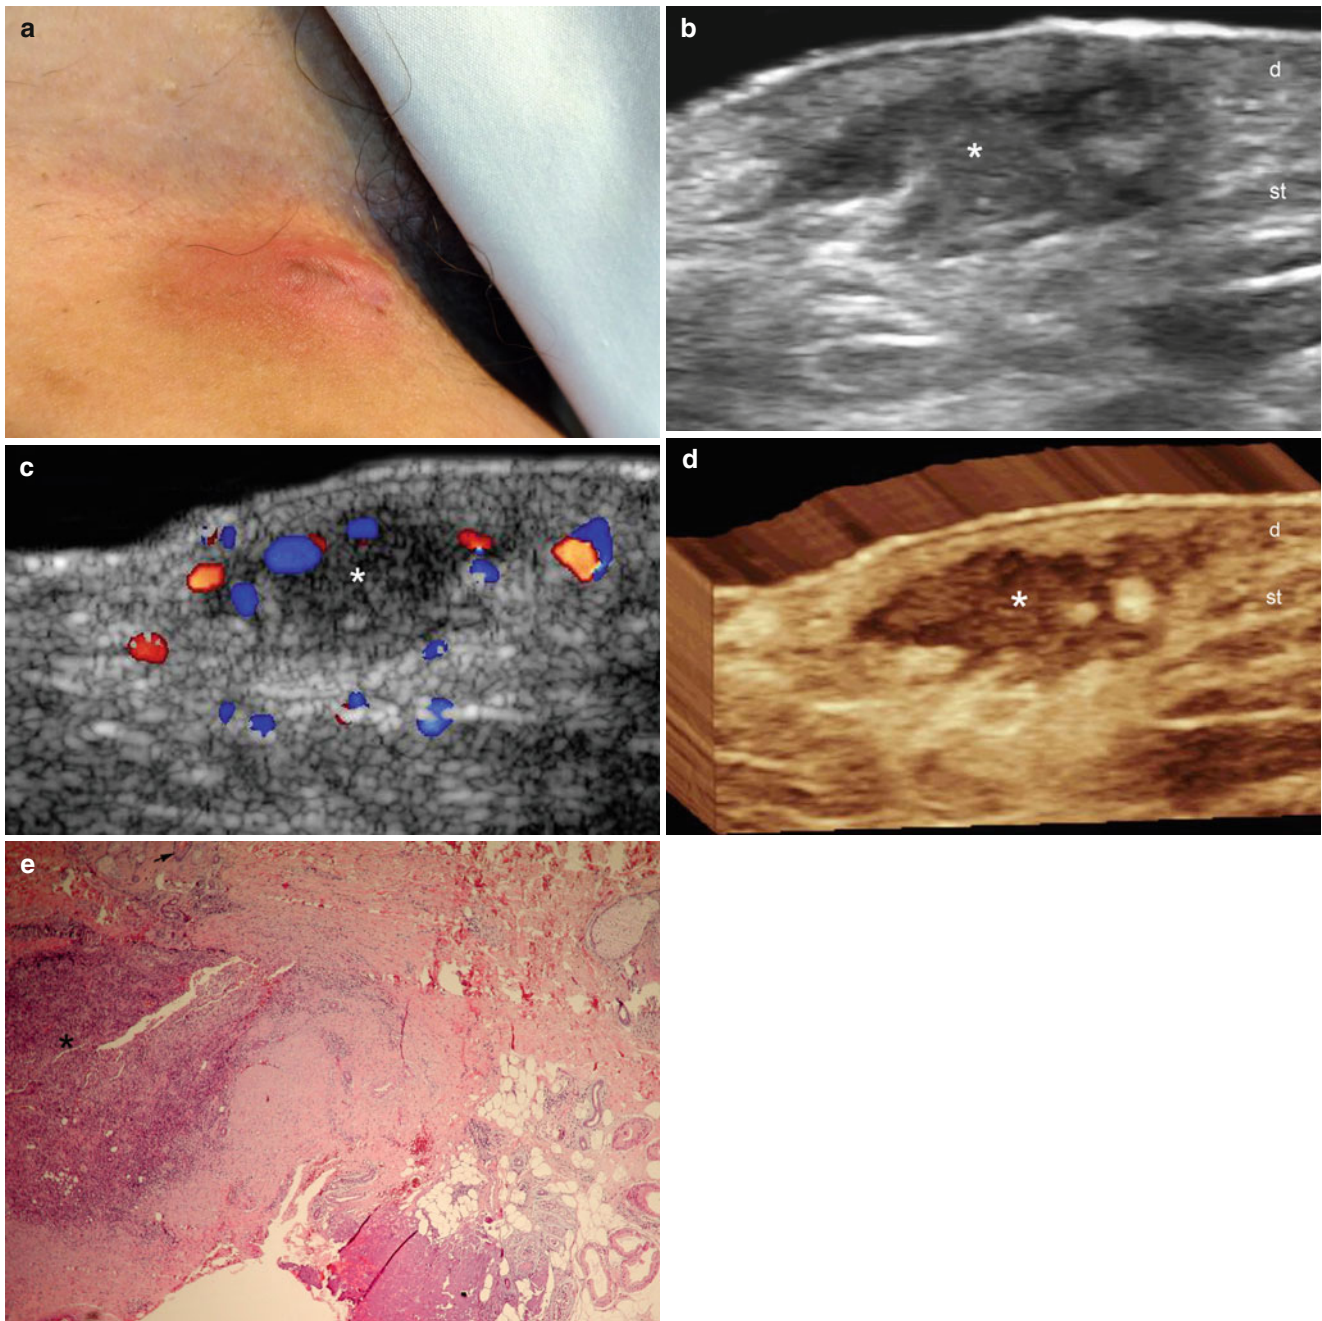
(a–e) Hidradenitis suppurativa. (a) Clinical image shows erythematous swelling in the right groin (Hurley II). (b) Gray scale ultrasound image (transverse view) demonstrates hypoechoic collection (*) with echoes (debris) and irregular borders in the dermis and subcutaneous tissue that connects to the base of the hair follicles. Thickening and decreased echogenicity of the dermis is also detected. (c) Color Doppler ultrasound image (transverse view) shows increased
